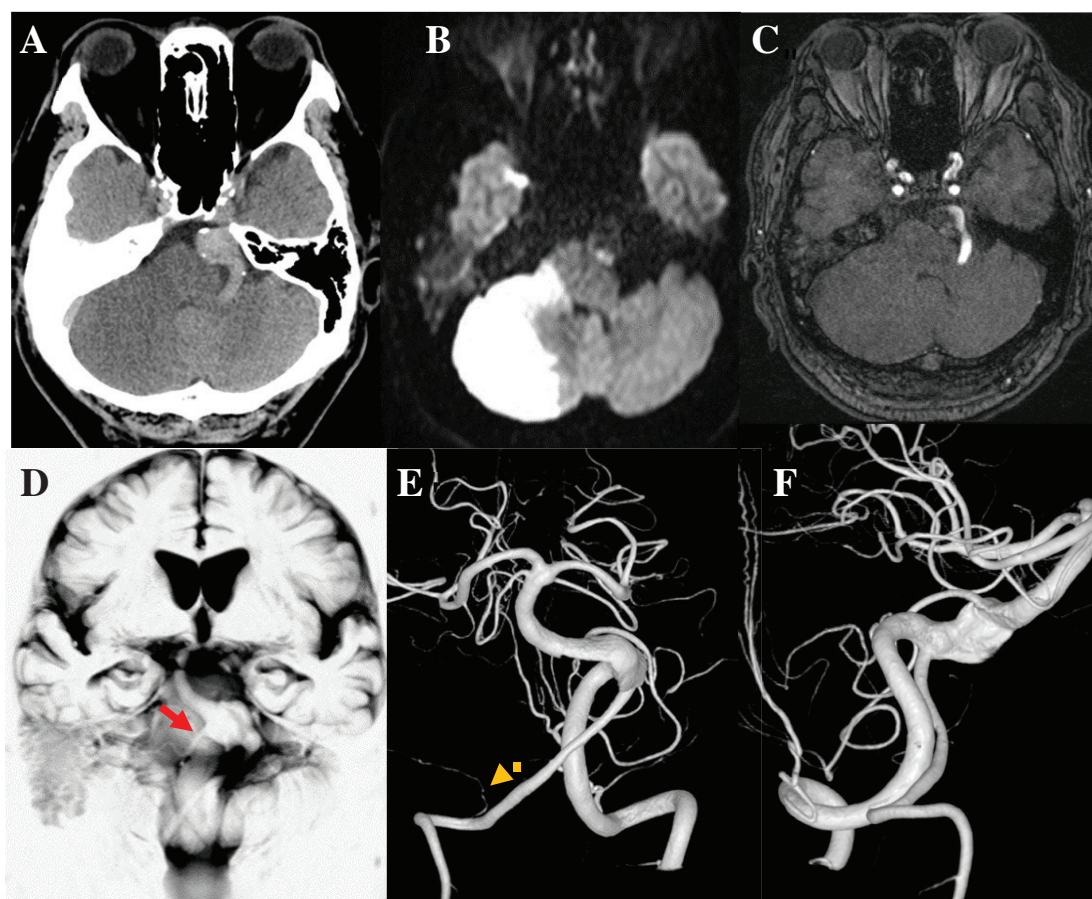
A-F, images acquired at the time of admission. Computed tomography (CT) showing a low-density area in the right cerebellar hemisphere and a 17-mm high-density area appearing aneurysmal (A). Magnetic resonance imaging (MRI) with diffusion-weighted imaging (DWI) showing fresh infarction in the right cerebellum and right lateral medulla (B). TOF (time of flight) MRA (C) showing signs of a double lumen in the basilar artery (BA). Basi-parallel anatomical scanning (BPAS) MRI (D) and magnetic resonance angiography (MRA) (E) showing BA dilatation and meandering, all of which suggested anterior inferior cerebellar artery (AICA); (red arrow) and posterior inferior cerebellar artery (PICA)(yellow arrow) occlusion due to thrombosed dissecting aneurysm associated with vertebrobasilar dolichoectasia (VBD).
